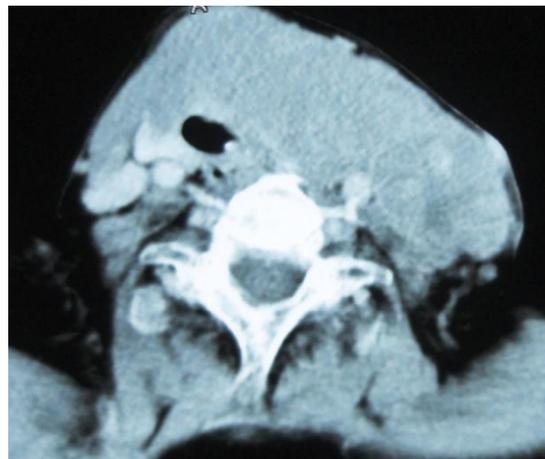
In this cervical CT image, diffuse enlargement of the left lobe of the thyroid gland (85x30 mm) with accompanying ipsilateral cervical lymphadenopathies, right tracheal deviation and compression can be seen.
